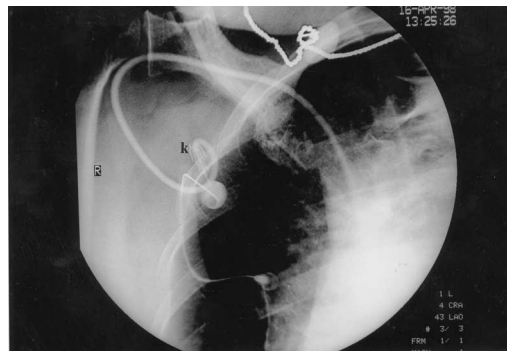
Port catheter twisting and kinking (k) present at the first chest X-ray post placement in the operating room. Imaging was improperly used during placement.
